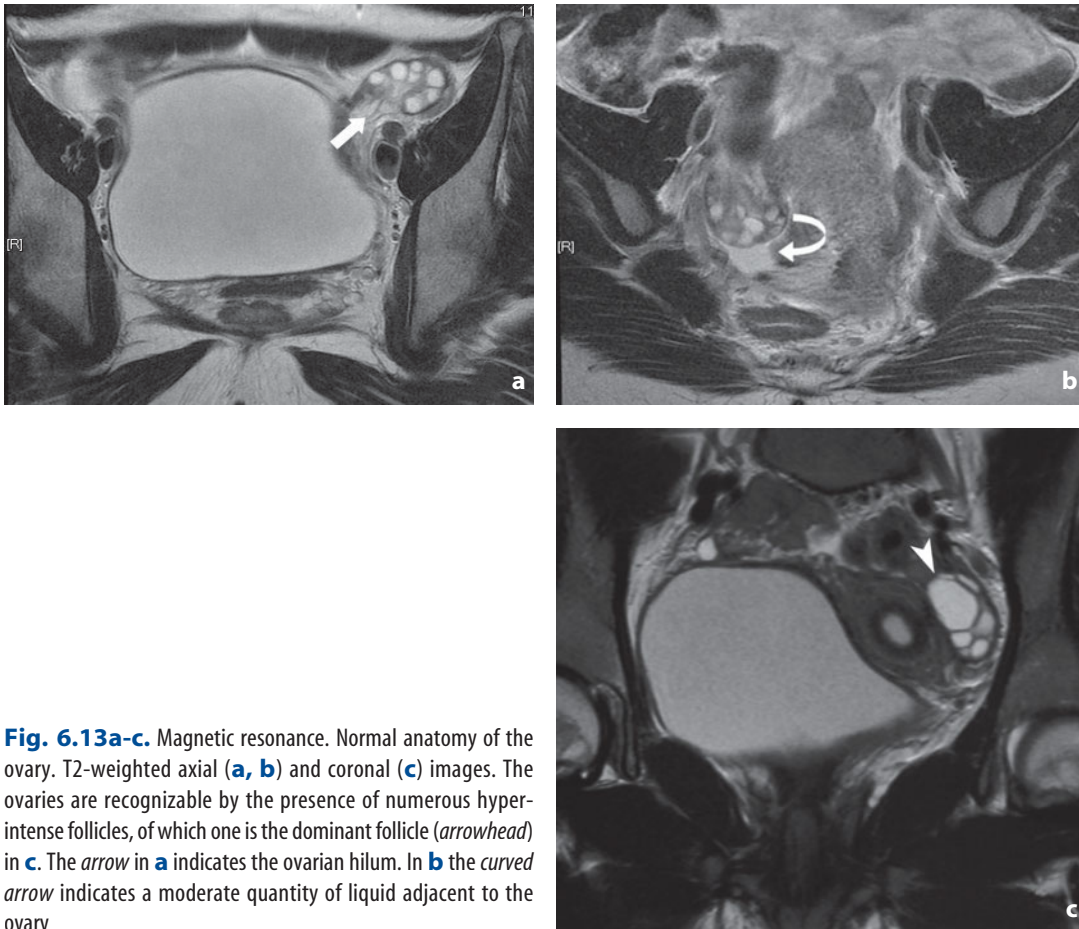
Magnetic resonance. Normal anatomy of the ovary. T2-weighted axial (a, b) and coronal (c) images. The ovaries are recognizable by the presence of numerous hyperintense follicles, of which one is the dominant follicle (*arrowhead*) in c. The *arrow* in a indicates the ovarian hilum. In b the *curved arrow* indicates a moderate quantity of liquid adjacent to the ovary
